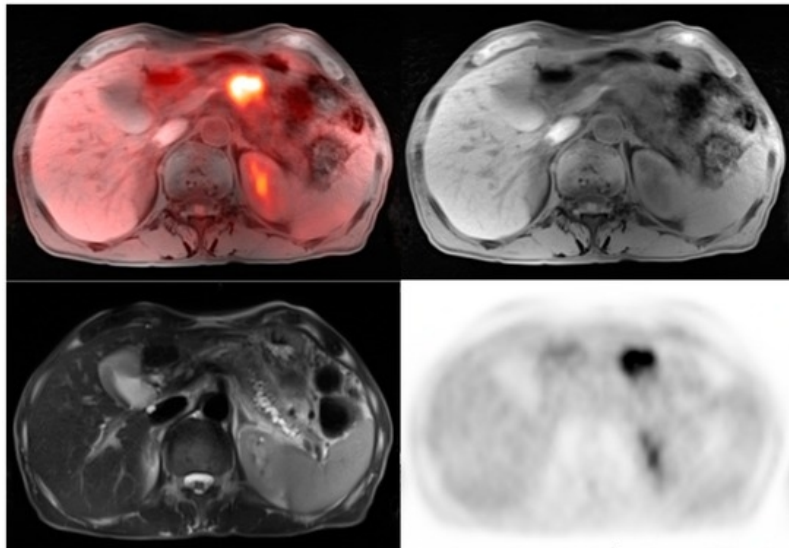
The top left panel shows an example of PET-MRI image fusion which indicates a likely tumorous region in the pancreas. The top right panel and bottom left are T_1 and T_2 weighted MRI images showing the structural abnormality in the pancreas region. The bottom right panel shows the original PET image which labels the likely tumorous region with dark pixels [4].
